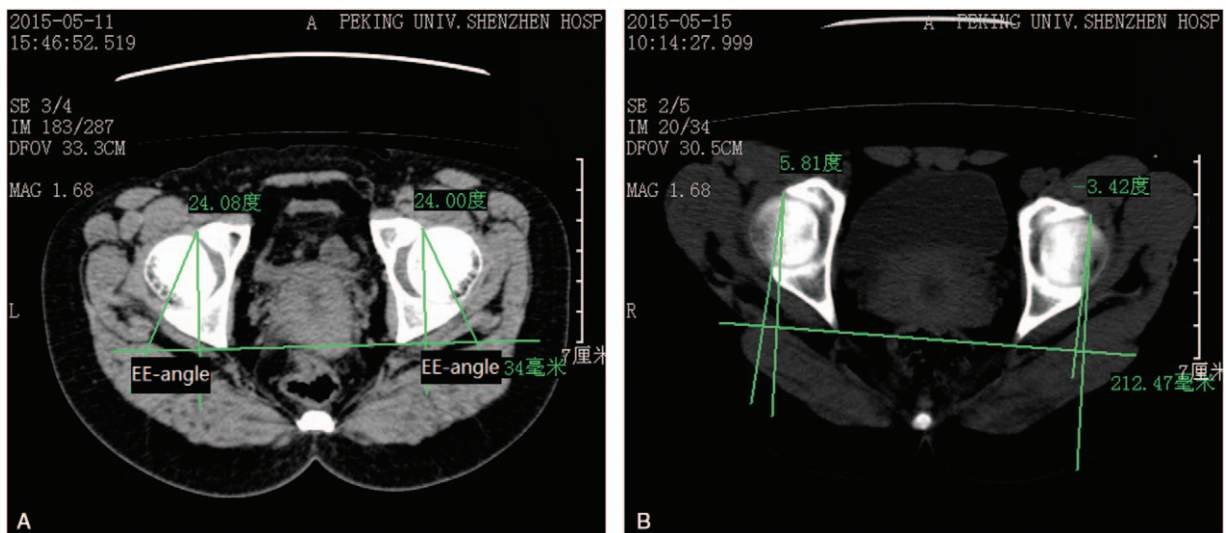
(A,B) The CT slice at the level of the maximum diameter of the femoral head. A line was drawn from the anterior to the posterior border of the acetabulum, as well as a line representing the sagittal plane. The EE angle was the angle which these 2 lines subtended. The graph shows 2 positive angles of (A), one positive and another negative of (B) as well.
